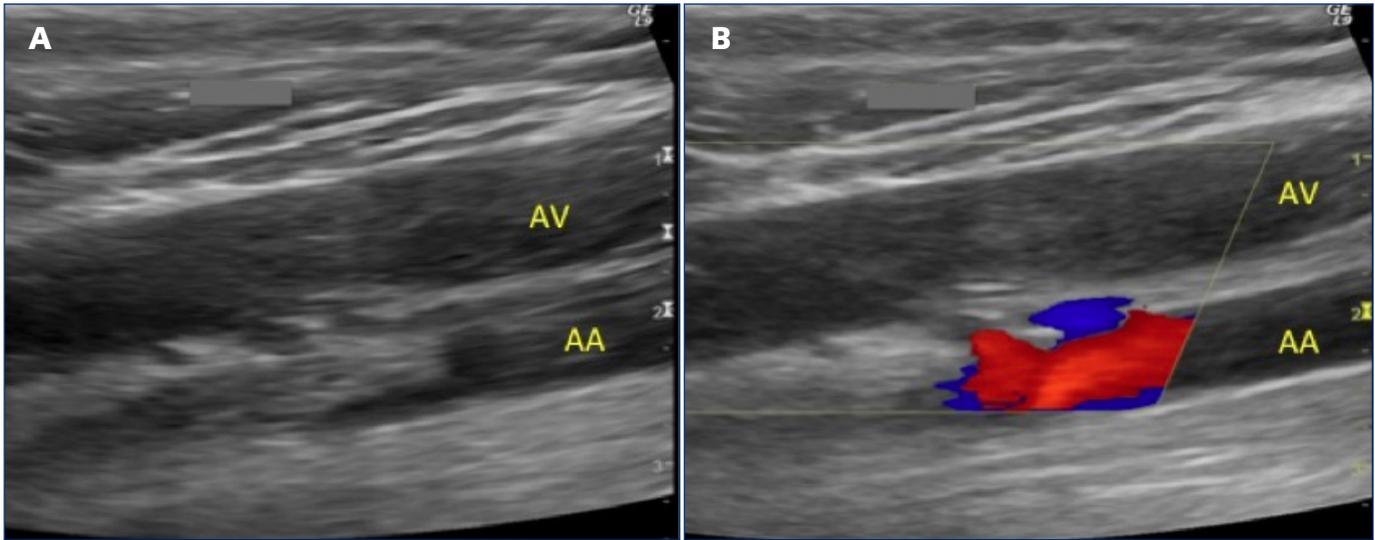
Greyscale image (A) showing axillary vein (AV) and artery (AA). The vein is dilated and filled with heterogenous echogenic material consistent with spontaneous thrombosis. Color Doppler (B) showing no flow within the vein demonstrating complete occlusion of the vessel. Red color in the axillary artery consistent with normal arterial flow.
